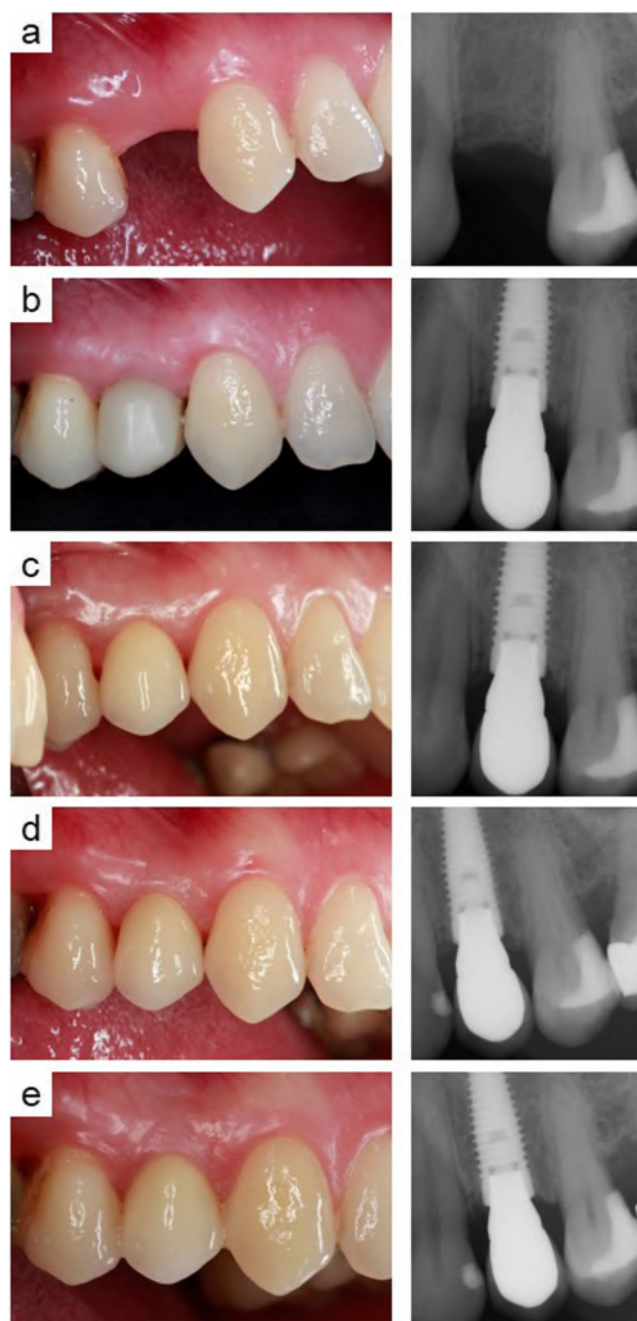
Representative clinical case from a 41-year-old healthy female, treated in maxillary position 24 with an anodized tapered implant with conical connection. The implant was restored with a cemented monolithic zirconia abutment and NobelProcera crown. Clinical view and periapical radiograph prior to surgery (a), at 6-month follow-up (b), at 1-year follow-up (c), at 2-year follow-up (d), and at 3-year follow-up (e)
